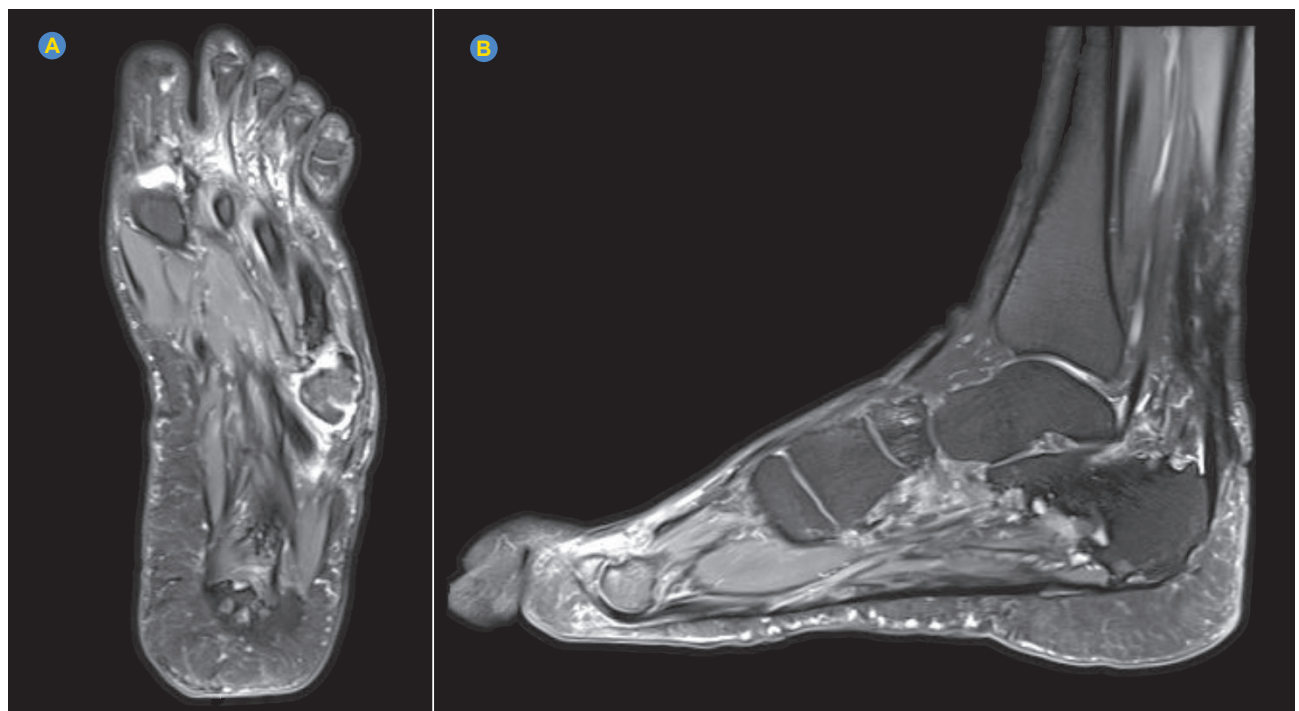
Post-treatment MRI of the left foot showing regression of the lesions and tissue edema, with bone sequelae
